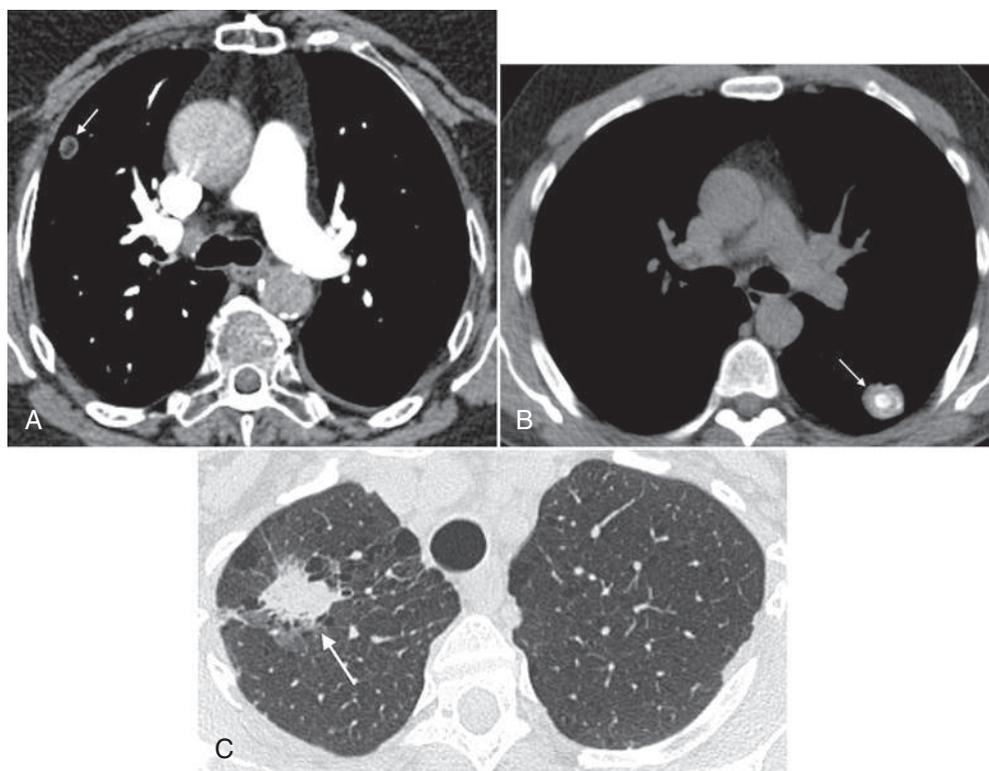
Computed tomography examples of solitary pulmonary nodules. A, Nodular density in the right lung that contains fat. Note the same density within the nodule as the subcutaneous fat. This finding is diagnostic of a pulmonary hamartoma, a benign diagnosis, requiring no further follow-up. B, There is central calcification with this pulmonary nodule, a benign form of calcification, and consistent with a granuloma. C, The spiculated edge of this nodule (*arrow*) is suggestive of malignancy in this biopsy-proved primary lung adenocarcinoma.
